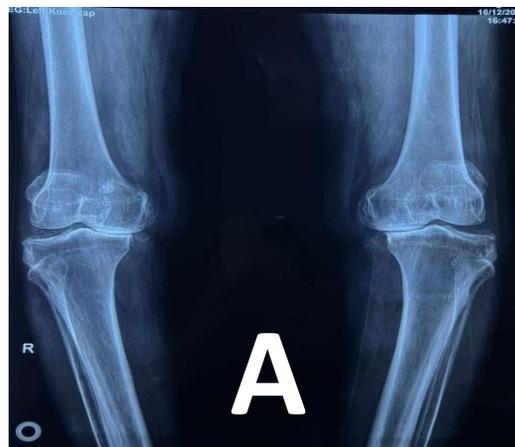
Pre (Anterio-Posterior and Lateral) – and post- operative radiographs of knee joint (TKR); A, B, and C respectively.
